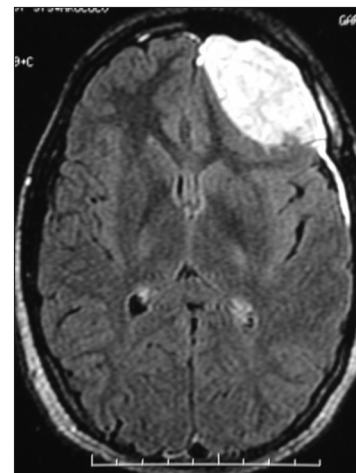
T2-weighted magnetic resonance imaging image showing left frontal extradural hematoma
